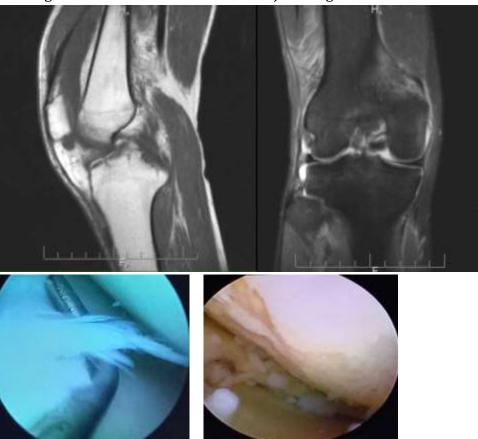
Patient V., 21 years old. MRI and arthroscopic studies of the right knee joint In 60 (29.4%) patients who underwent arthroscopy, no damage was found in the MM, LM, or ACL, which in the preoperative period in the MRI findings had different types of damage to either the MM, LM, or ACL. During diagnostic arthroscopy, there were all signs of meniscopathy and an enhanced pattern of the synovial membrane that appears in chronic synovitis in the knee joint; in these patients, during arthroscopy, we used Dekasan's solution for the purpose of joint lavash.
